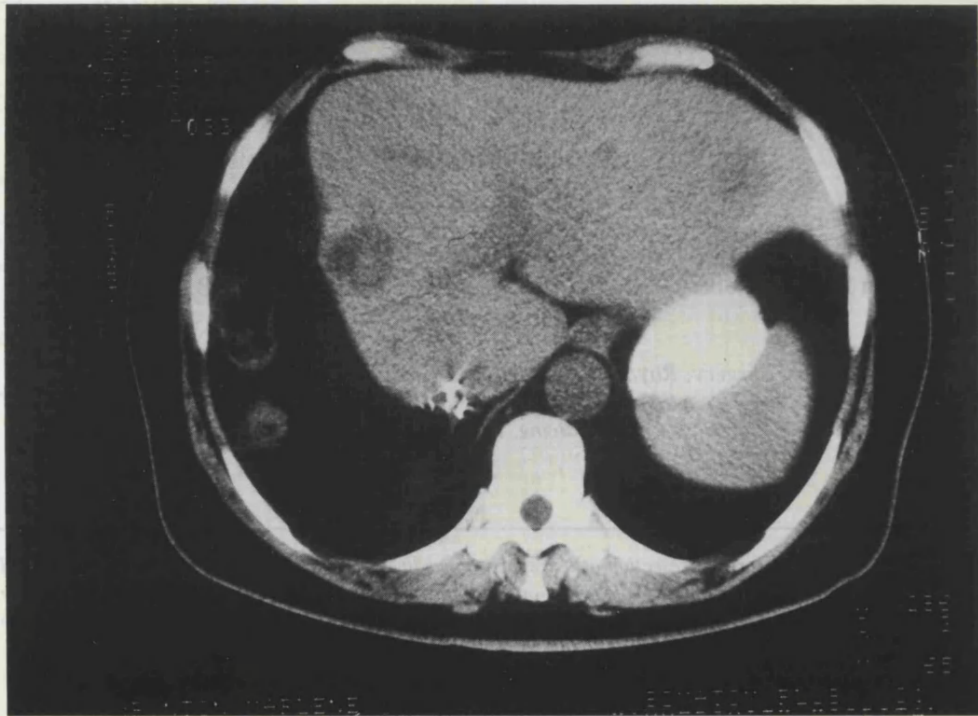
CT scan showing synchronous hepatocellular carcinoma (left) and liver adenoma (right).
